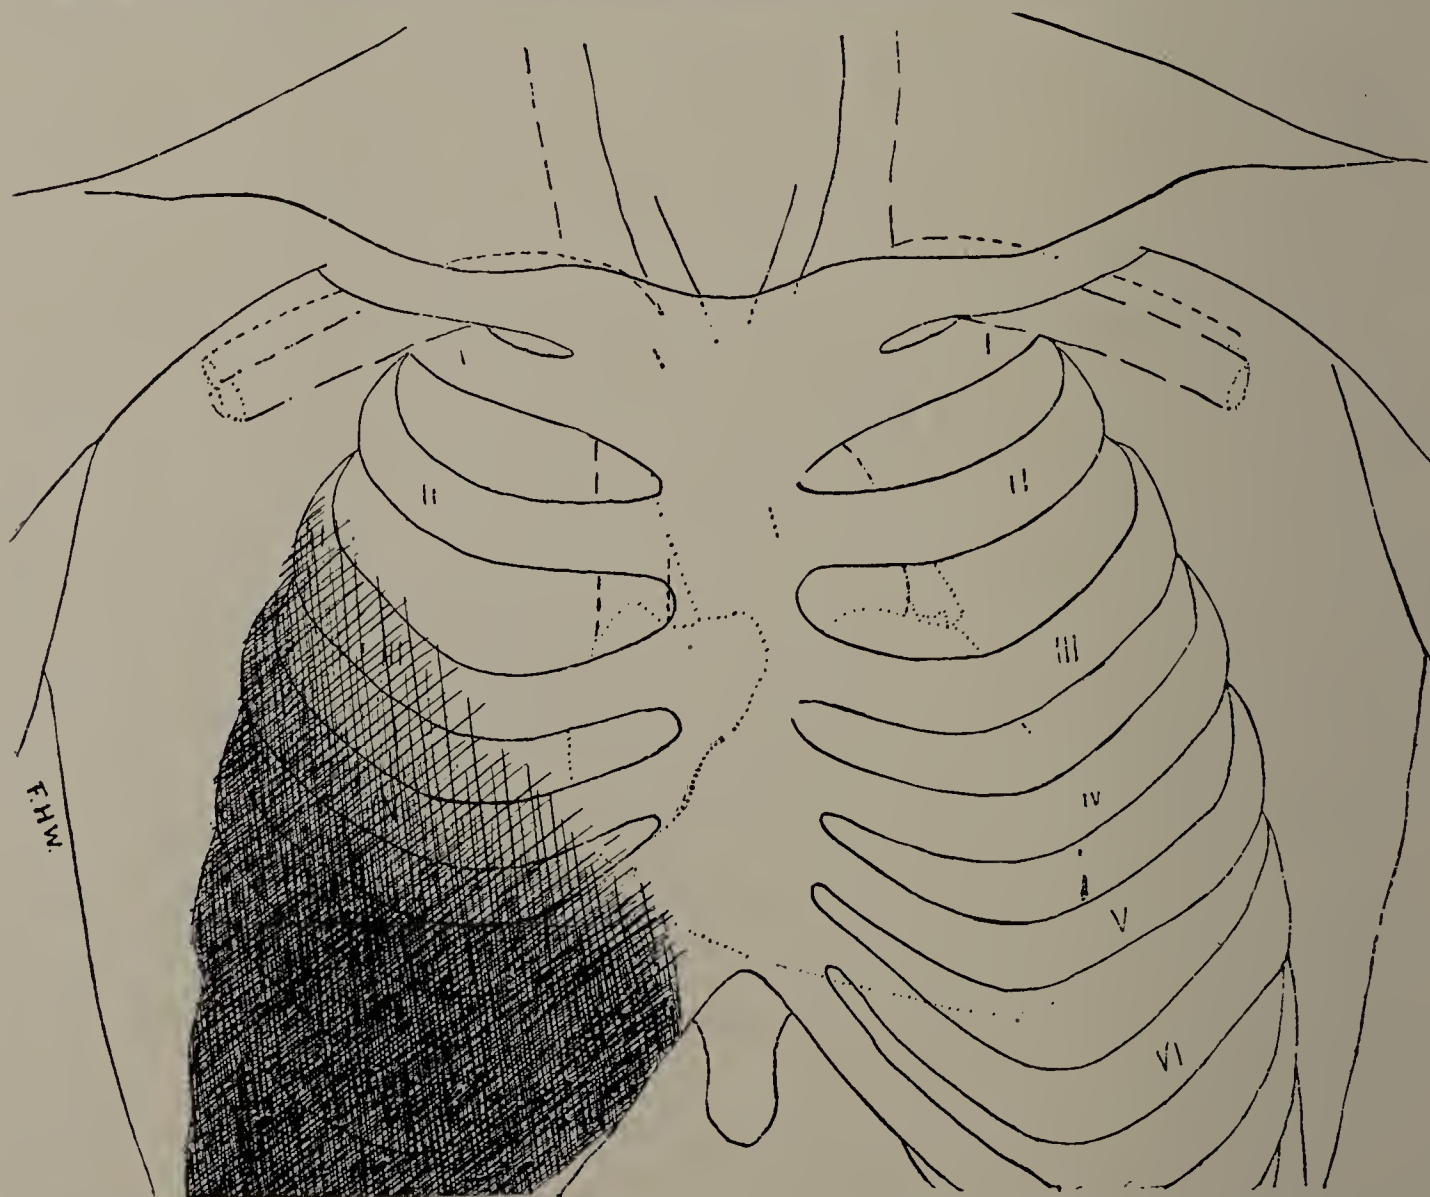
Mary E. H. Pleurisy with effusion. X-ray examination with screen September 4th. Darkened area on right side, running from junction of cartilage with sixth rib to outer end of right clavicle. (Cut one-third life size.)
